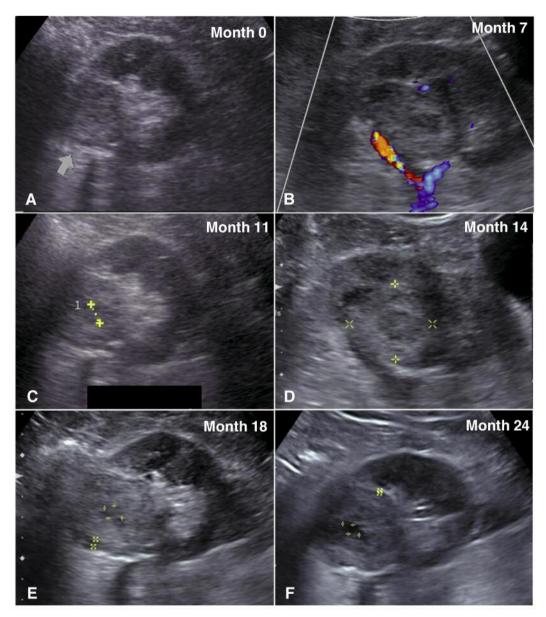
Kidney ultrasound evolution of the patient with clear-cell renal cell carcinoma during the first 24 months of treatment with Viscum album extract. A peritumoral halo and necrotic area were observed from month 7 until month 30 (last follow-up). A-F: Ultrasound images from 0, 7, 11, 14, 18, and 24 months, respectively. Arrow in A: The tumor.
